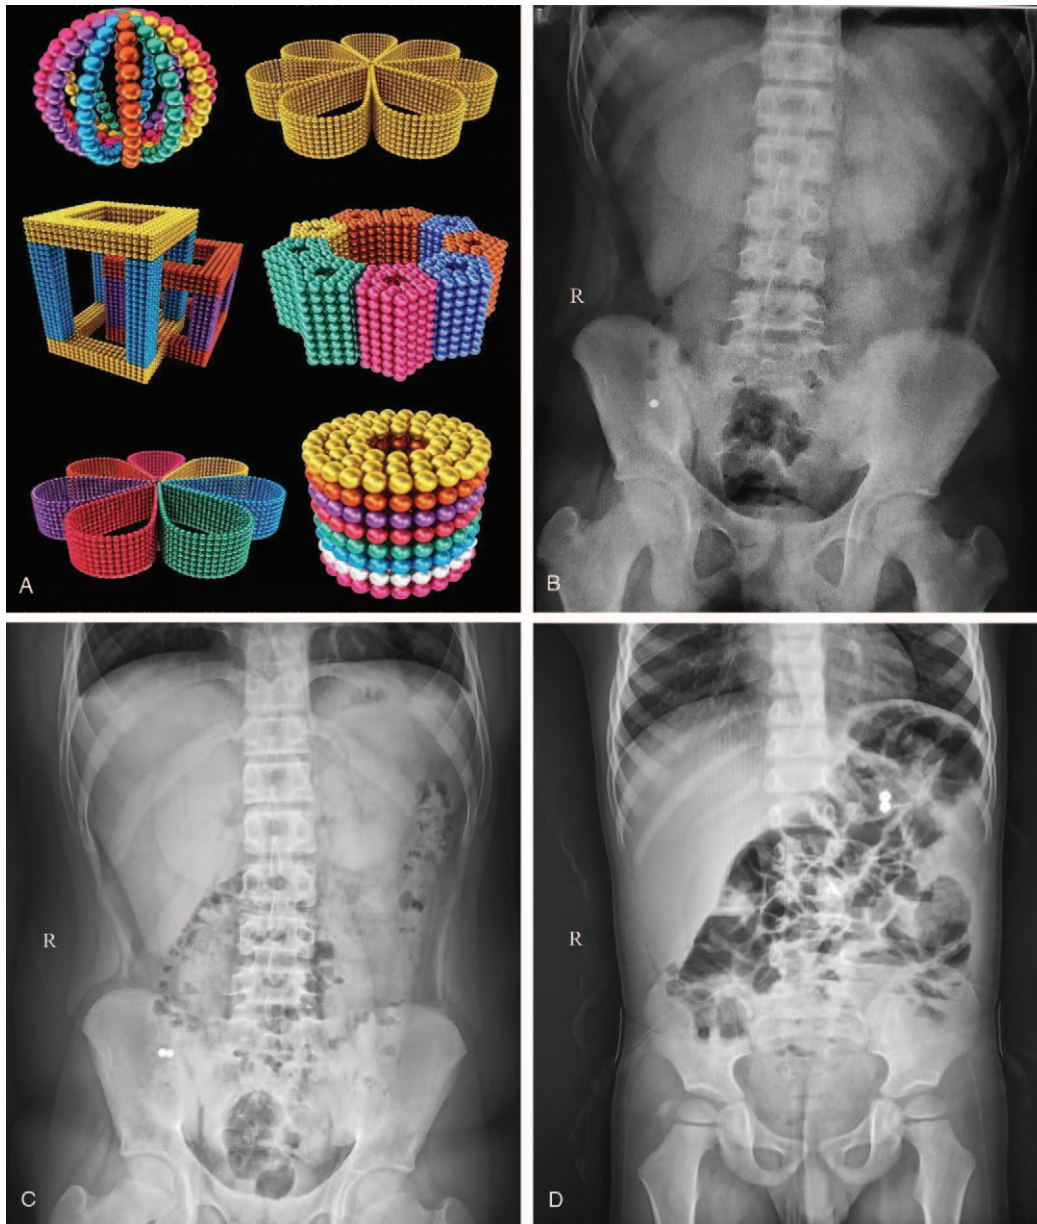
Imaging of Buckyballs ingestion. (A) Rare-earth neodymium magnets (Buckyballs). (B) Two Buckyballs overlapped on a single view and were misdiagnosed as a single Buckyball. (C) Another abdominal radiography of the same patient shown in (B). (D) Buckyballs in the stomach and colon attracted each other appeared as all the Buckyballs were still in the stomach.
